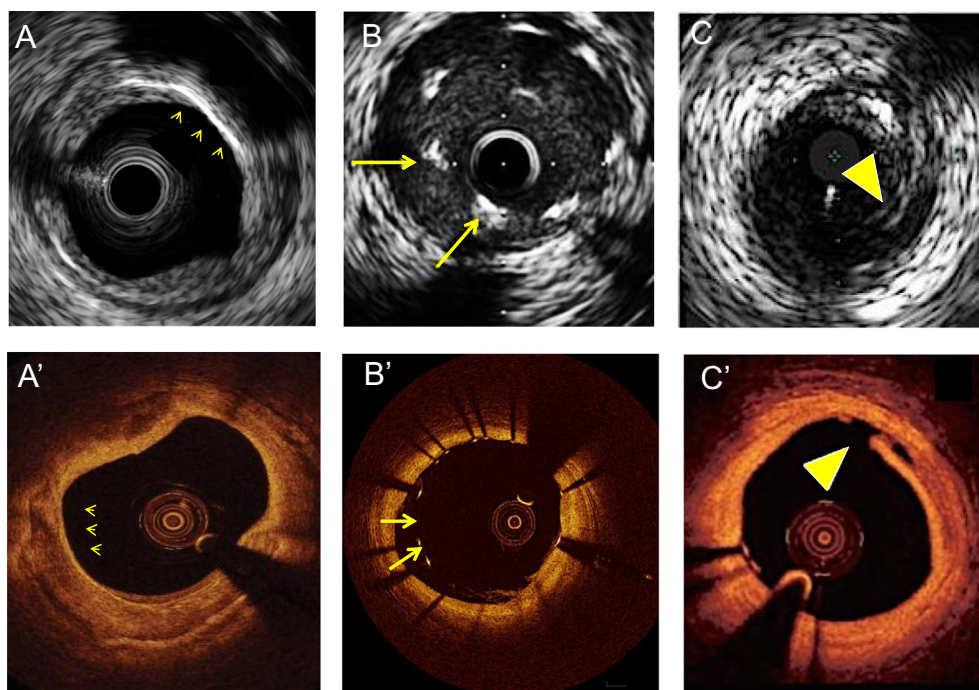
Features visualized by intravascular coronary imaging. Panel A and A': example of calcifications (yellow arrowheads) at intravascular ultrasound (IVUS) and optical coherence tomography (OCT), respectively. Panel B and B': example of incomplete stent apposition (ISA) at IVUS and OCT, respectively. Panel C and C': example of stent edge dissection (flap indicated by yellow arrowhead) at IVUS and OCT, respectively. IVUS and OCT images are taken from different coronaries of different patients.
